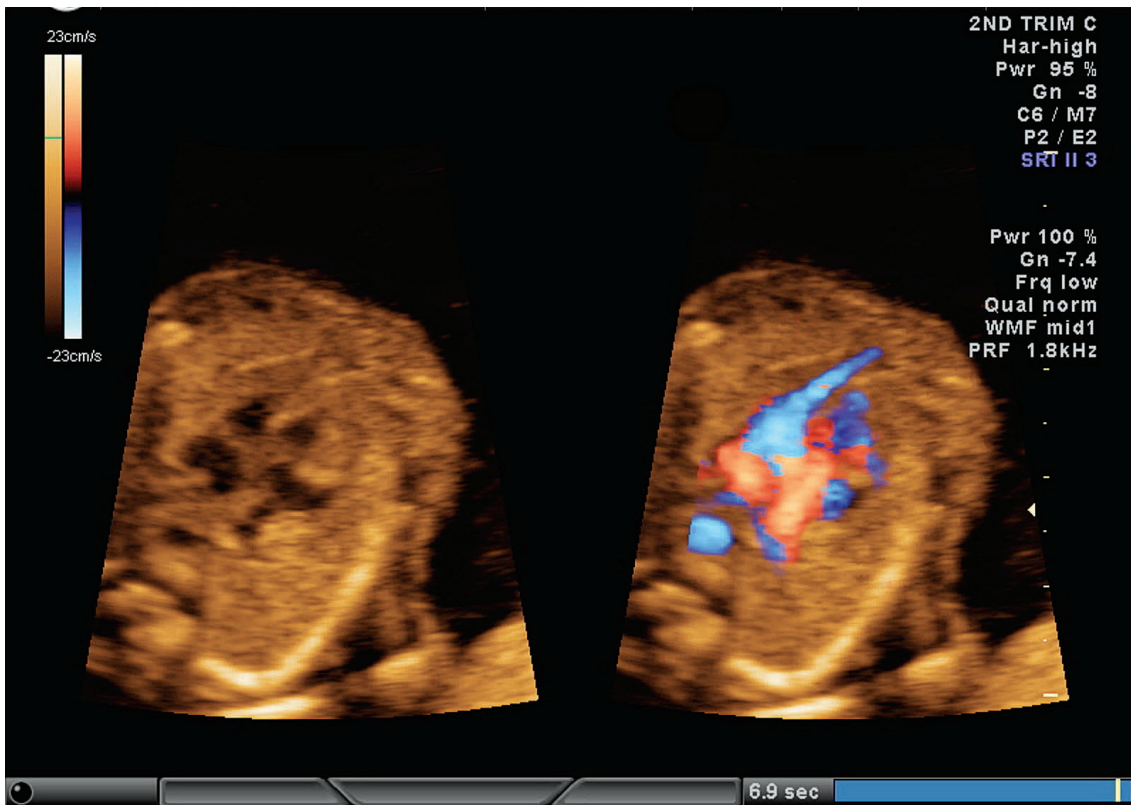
Colour Doppler imaging of the four-chamber view demonstrating the left ventricular diverticulum.
